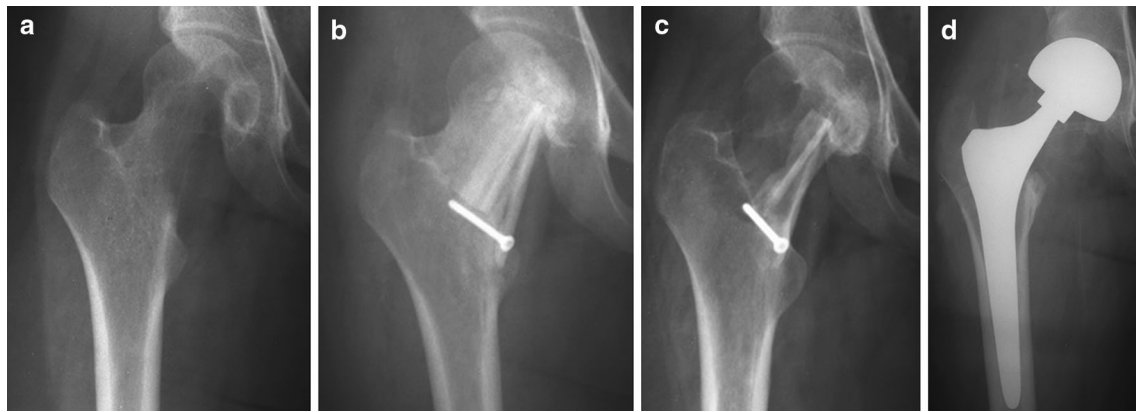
GCT of the right proximal femur on a 17-year-old girl: a anteroposterior preoperative radiograph shows lytic lesion involving the right proximal femur. b Anteroposterior radiograph showing the result after curettage and filling the bone defect with bone allografts.
